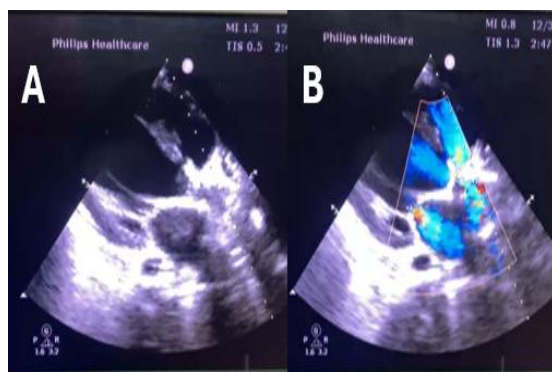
Transthoracic echocardiography demonstrating severe calcific aortic stenosis. A: two-dimensional parasternal long axis view showing markedly thickened and heavily calcified valve leaflets with extension of calcification to ascending aorta. B: color doppler imaging revealing turbulent high velocity flow across the aortic valve.
